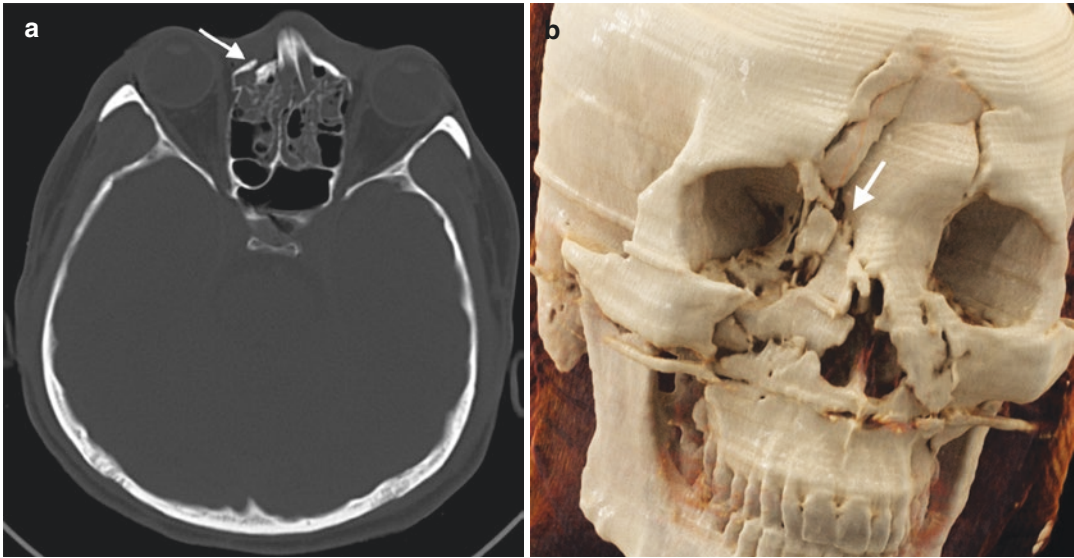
Type III NOE fracture in a 19-year-old man with a history of MVA. (a) Axial CT image reveals right NOE fracture involving nasolacrimal duct (arrow). (b) CR
